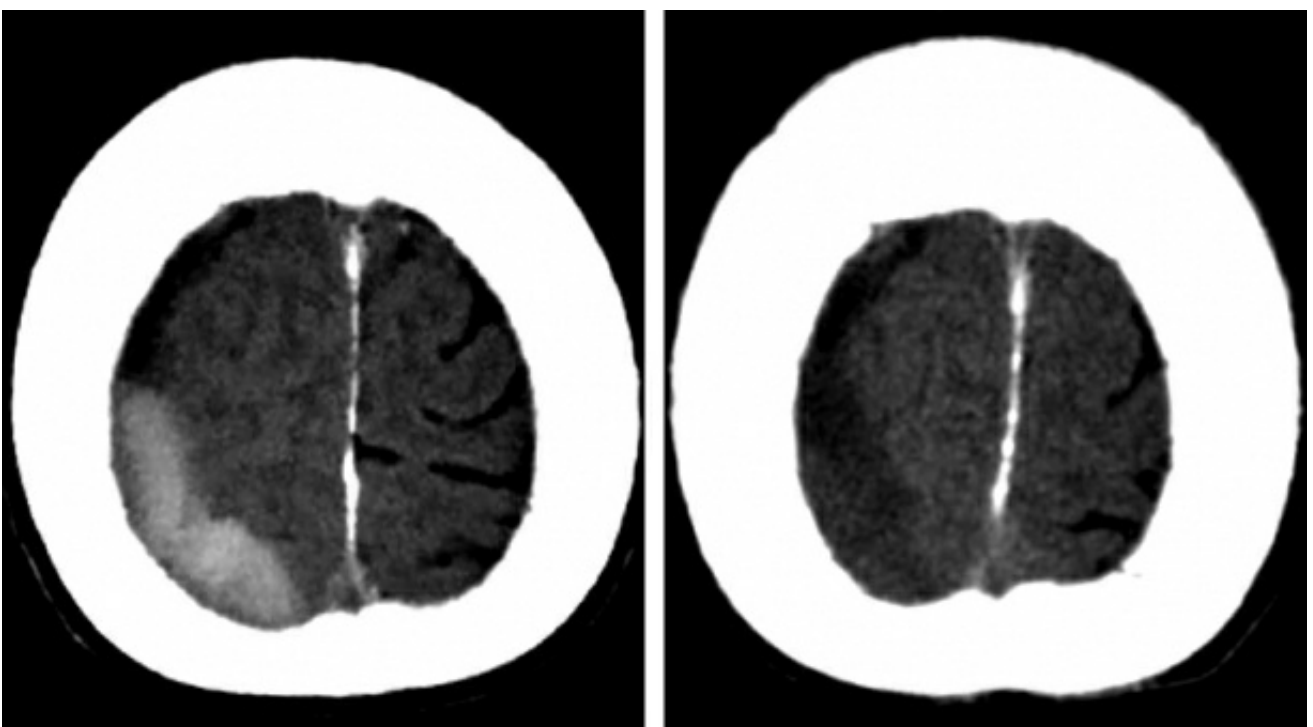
Axial CT images near the vertex demonstrate a dense acute hematoma superficial to the right parietal lobe (left) and a low density chronic subdural hematoma in the same patient 2 weeks later (right).
